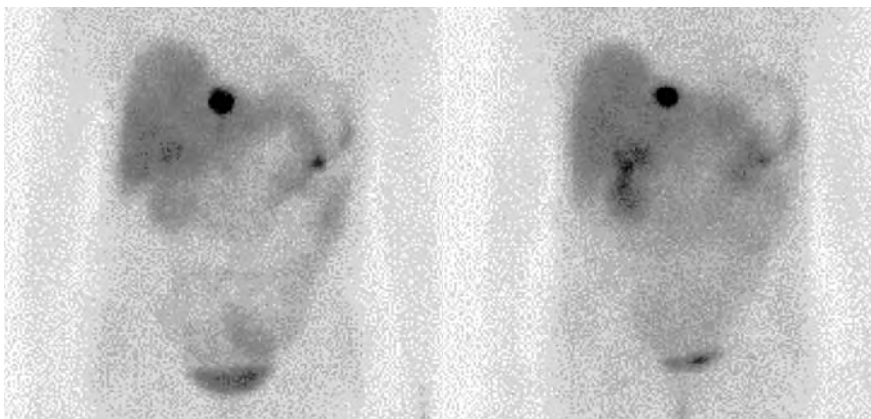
Comparative scintigraphy in a carcinoid tumor patient with a solitary liver lesion using two different technetium-99m somatostatin analogs. (Courtesy of Dr. Gabriel, Innsbruck)
